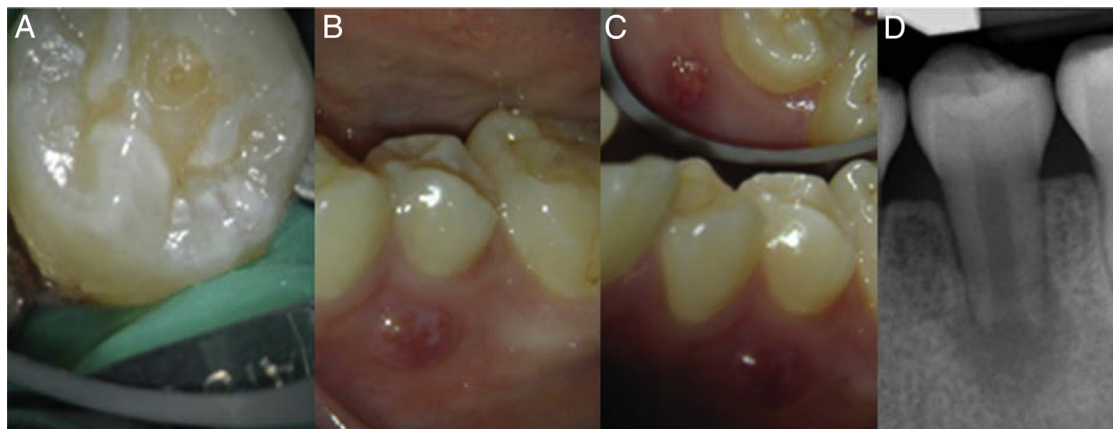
Preoperative photographs and radiographs. (A) Dens evaginatus with tooth #20. (B and C) Buccal and lingual sinus tracts associated with tooth #20. (D) A periapical radiograph depicting periapical radiolucency associated with tooth #20 with an immature apex and the absence of any caries lesions.
